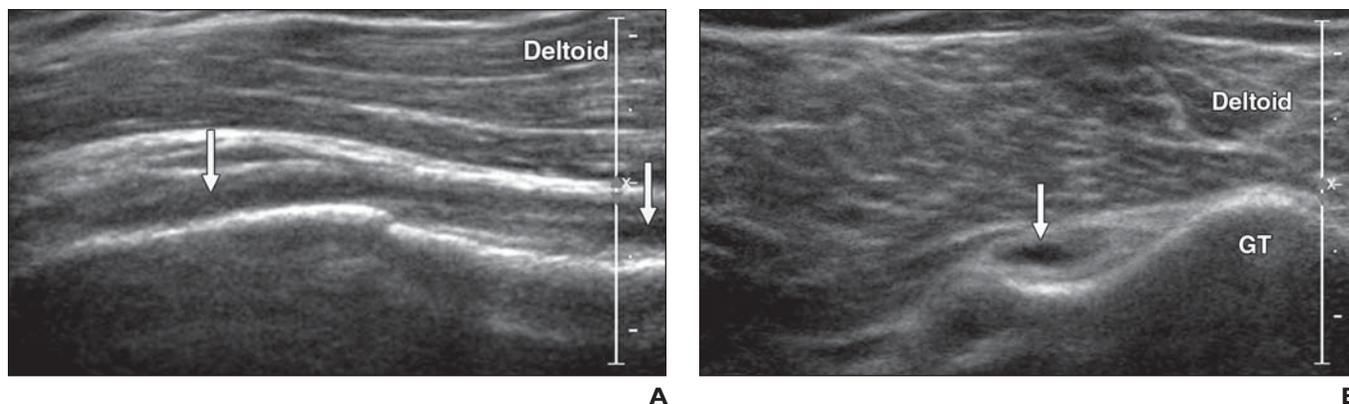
54-year-old man with asymptomatic full-thickness tear of tendon of long head biceps brachii muscle. A and B, Long-axis (A) and short-axis (B) ultrasound images (in relation to bicipital groove) show complete absence of biceps brachii long head tendon with residual fluid (arrows) in bicipital groove. GT = greater tuberosity.
